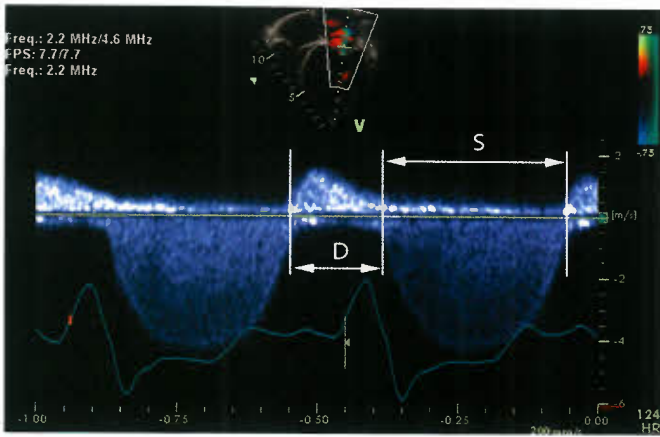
Continuous wave Doppler of mitral regurgitation in a child with dilated cardiomyopathy. The duration of mitral regurgitation represents the systolic duration (S). The remainder of the cardiac cycle represents diastolic duration (D). In ventricular dysfunction, systolic duration is prolonged compromising diastolic duration. This problem is aggravated by the relatively fast heart rate of 124 beats per minute in this patient where systolic duration is twice that of diastolic duration.
